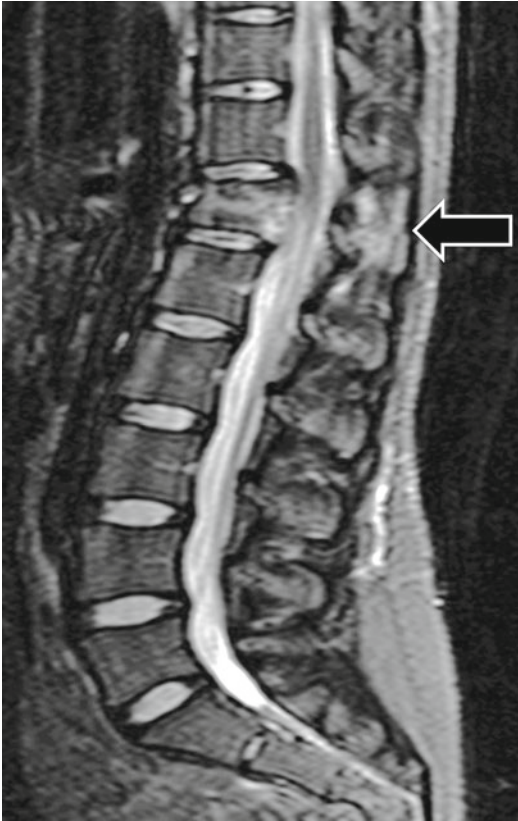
Sagittal short-tau inversion-recovery (STIR) MR image of the T12 Chance fracture shown in Fig. 4.23. The increased T2-weighted signal in the posterior elements (*white arrow*) on the sagittal image is indicative of the distraction injury to the interspinous ligament
